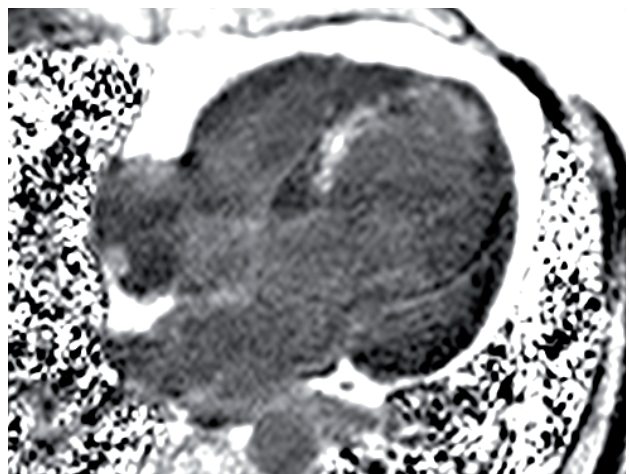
Cardiac magnetic resonance imaging. Image obtained with fat suppression. See explanation in the text.
